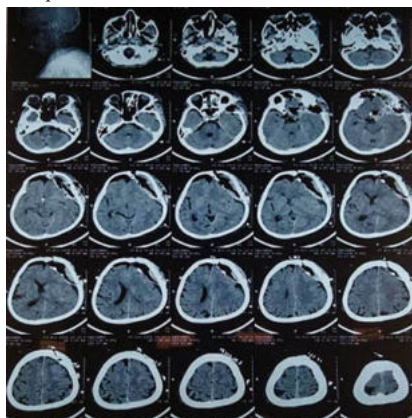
Postoperative computed tomography showing mass effect on left lateral ventricle and midline shift of 8mm to right
